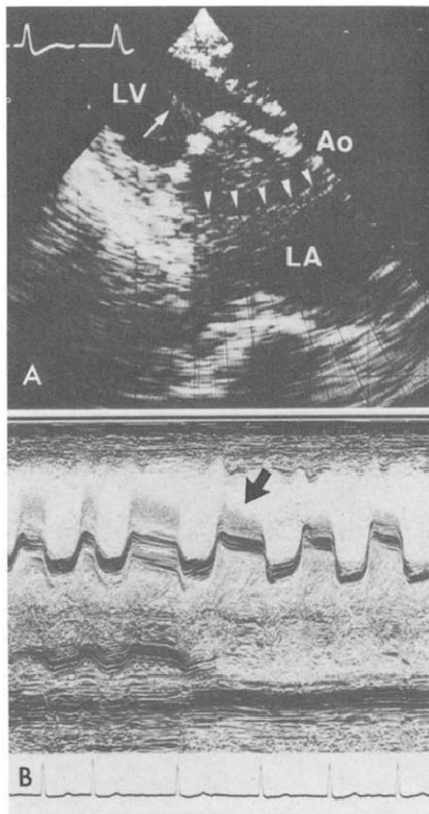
A, The smoke-like echo is noted behind the anterior mitral valve leaflet. It is ejected from the mitral orifice to the left ventricular (LV) cavity (arrow). The echo (arrowheads) in the left atrial (LA) cavity is an artifact echo generated by the side lobe of the ultrasound. B, An M-mode scan from the apical site to the basal site of the mitral orifice. The smoke-like echo ejected into the left ventricular cavity is in front of the anterior mitral valve leaflet during diastole (arrow). Ao = aorta.
